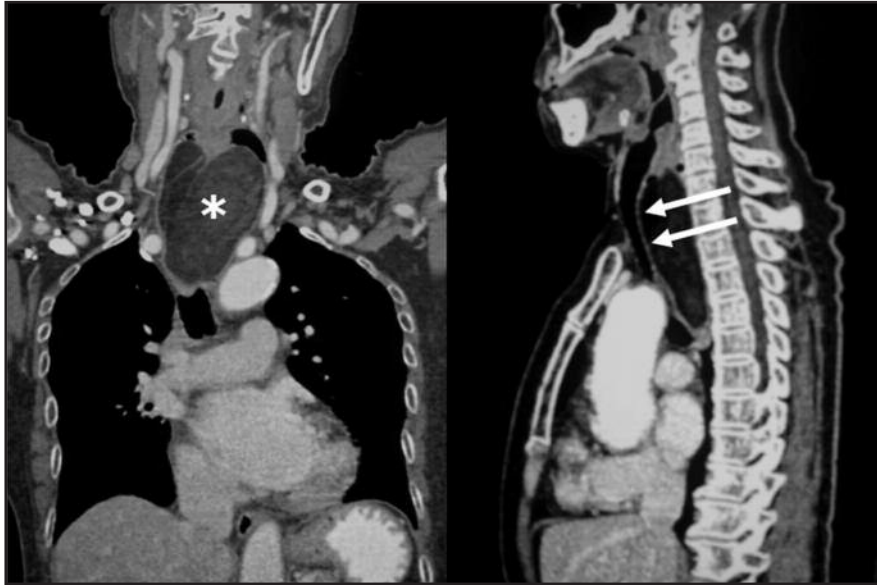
a) Reconstructed computed tomographic images showing a large lobulated tumour (asterisk) arising from the hypopharynx region extending down into the thorax alongside the oesophagus, b) reconstructed sagittal view showing compression of the trachea (Arrows).
